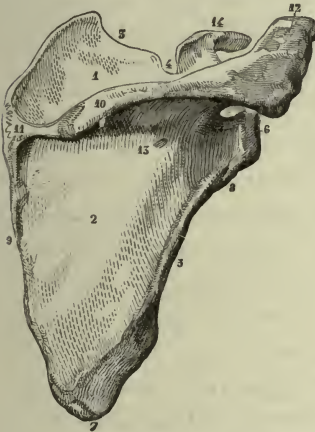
SCAPULA, POSTEROEXTERNAL ASPECT.
